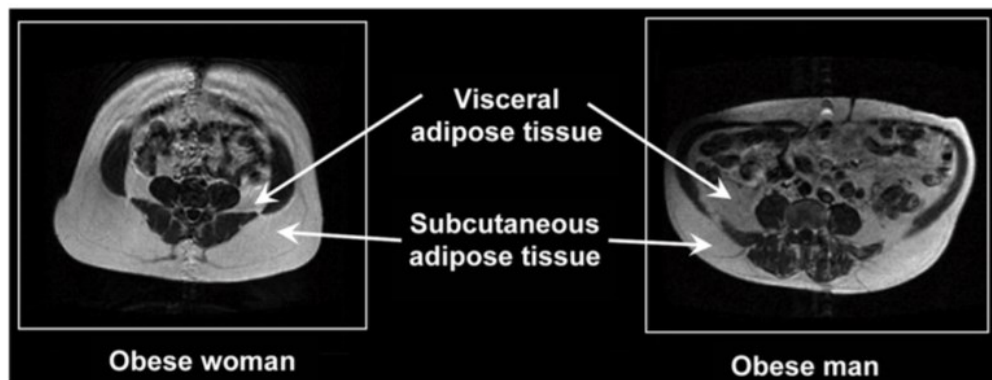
Cross-sectional abdominal magnetic resonance images of an obese female and an obese male ¹³.
